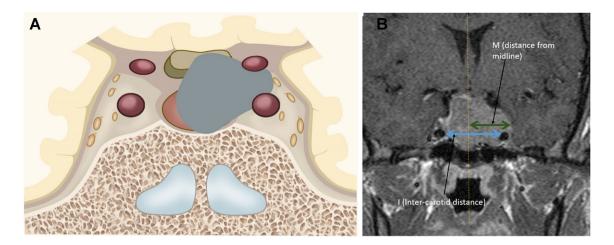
A Coronal CT slice of and illustartion of the Hypophyseal Fossa. B Blue line is the intercarotid distance we call this variable I; golden line is the midline; and the dark green line is the distance between midline and lateral maxima which we call M
